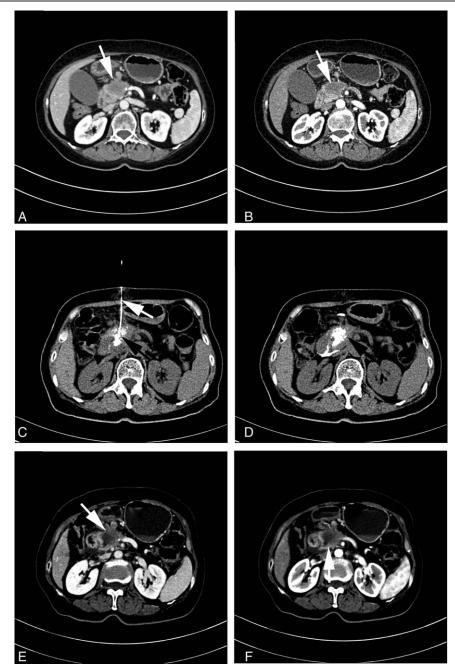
Preoperative and postoperative computed tomography (CT) scans (A, B) Axial CT showing carcinoma in the head of the pancreas (white arrow); (C, D) CT images during percutaneous intratumoral injection with gemcitabine plus cisplatin mixed with fibrin glue (black arrow); (E, F) 2 days after the treatment, CT showing tumor necrosis (white arrow).
